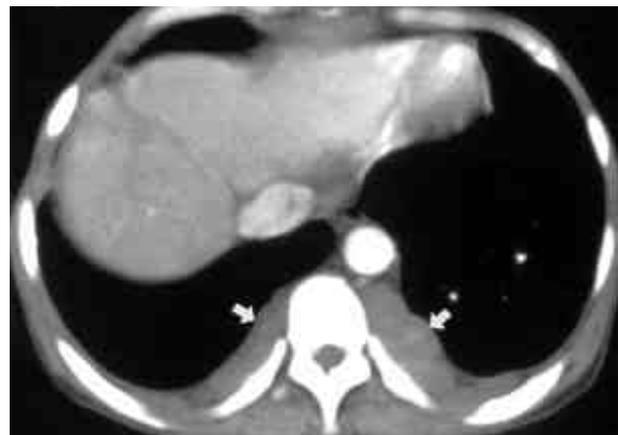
Enhanced CT scan shows bilateral paravertebral masses (arrows). The masses appear with smooth margin, homogeneous attenuation and mild enhancement. No evidence for vertebral body erosion or mass effect against the adjacent aorta is noted.
